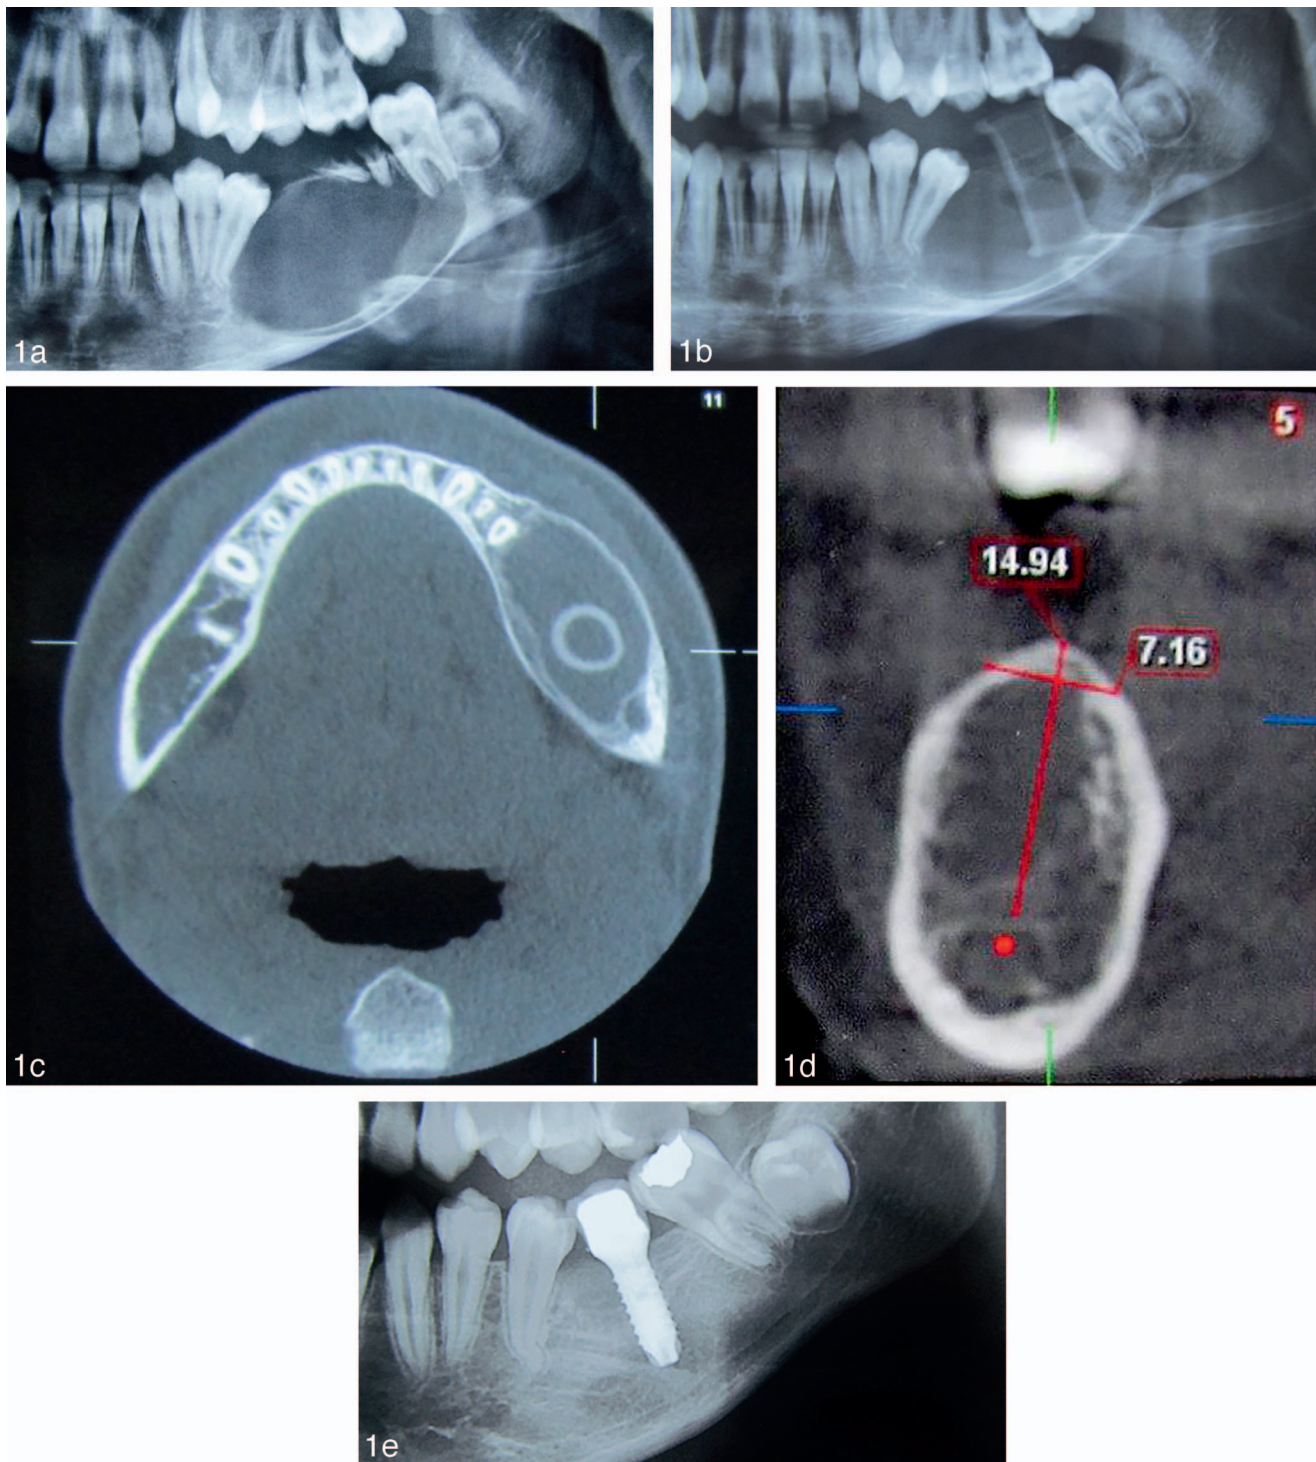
(a) Large periapical cyst. (b) Marsupialization device. (c) Postmarsupialization cone beam computerized tomography (CBCT) after 2 months. (d) CBCT 1 year after operation. The apically displaced inferior dental canal remained near the inferior border. This allows a long implant to be inserted. (e) A dental implant replaced the lost tooth. After removal of the marsupialization device, part of the space closes spontaneously.
